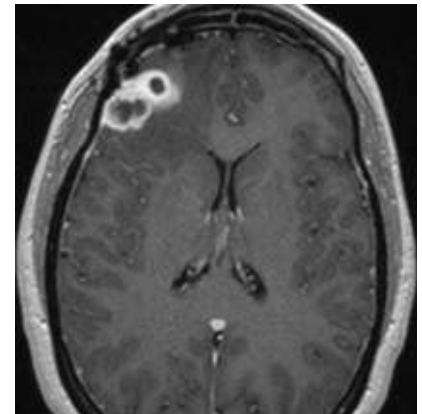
Brain abscess. Post-contrast MRI of the brain shows ring-enhancing lesions in the lateral right frontal lobe, with “daughter” lesions (smaller adjacent rings of enhancement) also noted. (Reproduced with permission from USMLE-Rx.com.)
